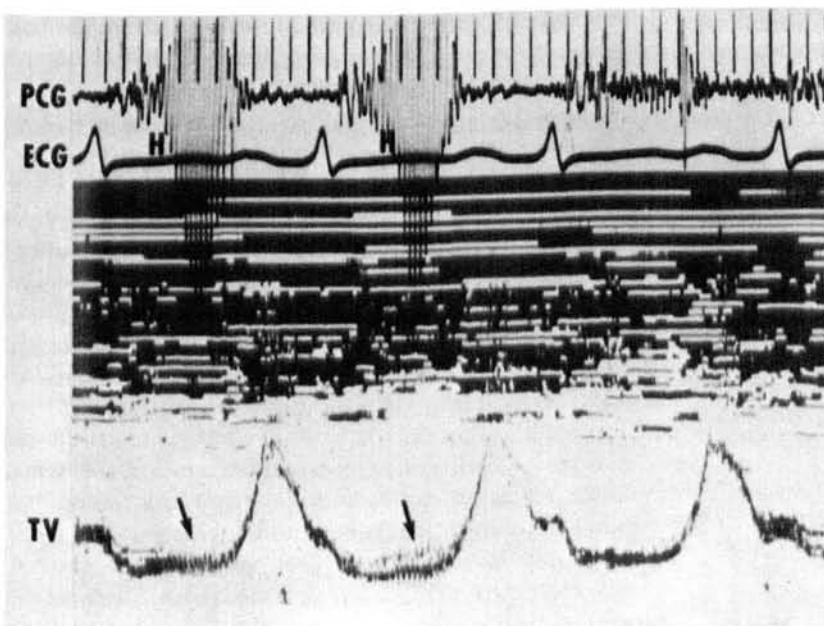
Simultaneous phonocardiogram (PCG) and echocardiogram of the tricuspid valve (TV) from case I showing systolic honking (H), coincident with the systolic fluttering (arrow) in the first two beats, while honk and fluttering are absent in the third beat.
